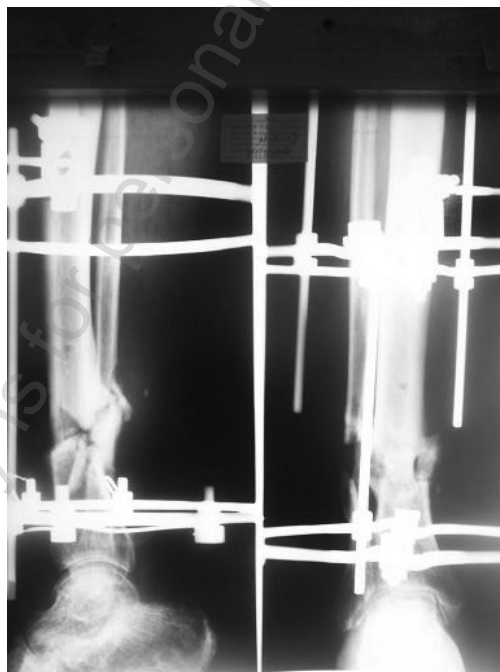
Showing the radiograph of the docked site
